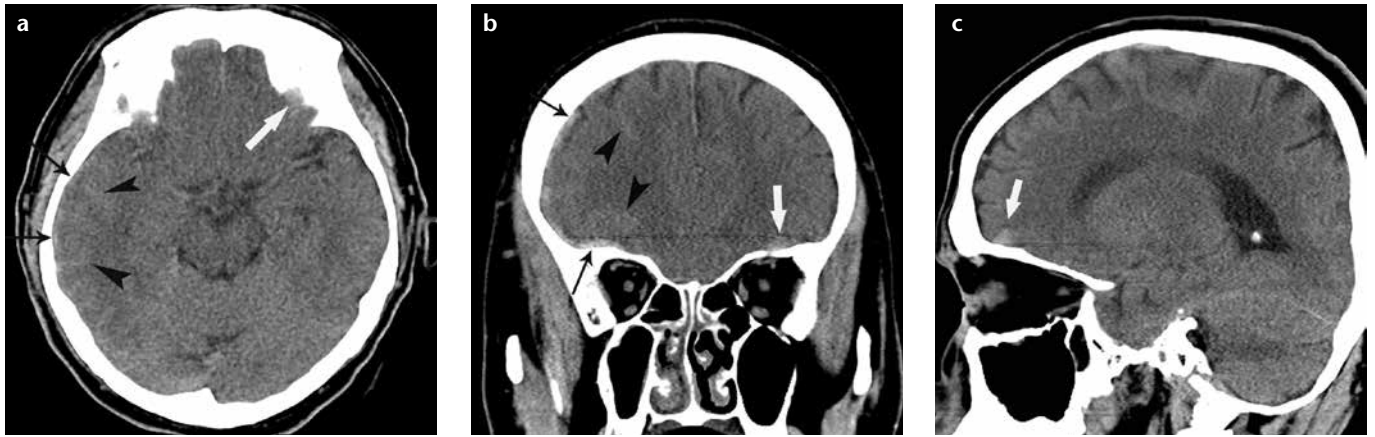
a–c. A 48-year-old male with head trauma. Unenhanced transverse CT image (a) shows a small right subdural hematoma (*black arrows*) that was identified only by the neuroradiologist (missed by all three radiology residents), and a questionable contusion in the left inferior frontal lobe (*white arrow*) that was missed by all four readers. Coronal (b) and sagittal (c) reformatted images show a small right subdural hematoma (b, *black arrows*) and a small left inferior frontal lobe contusion (b, c, *white arrows*), which were identified by all four readers. Additionally, there is a right temporoparietal subarachnoid hemorrhage (a, b, *arrowheads*), which was identified by all four readers.
